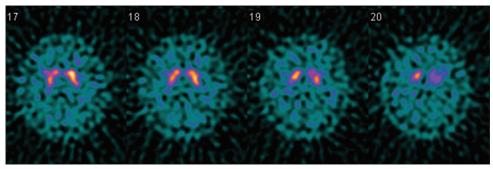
Single photon (SPECT) imaging obtained following the injection of Iodine-123 Ioflupane (DaTscan). The images show a normal distribution of dopamine reuptake transporters at the presynaptic terminals within the striatum bilateral. The findings are inconsistent with Parkinson's disease
